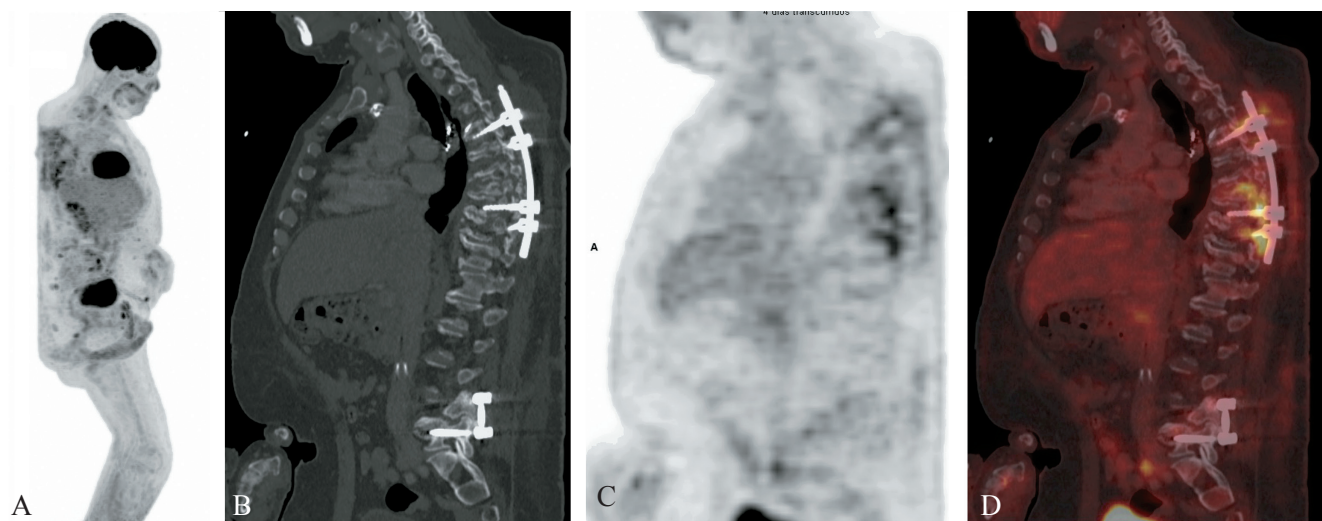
MIP image (A) and sagittal CT (B) PET (C) and PET/CT fusion (D) images showing postoperative spondylodiscitis with increased ^{18}F -FDG uptake around the spinal implants and the surrounding soft tissues at multiple contiguous levels.
